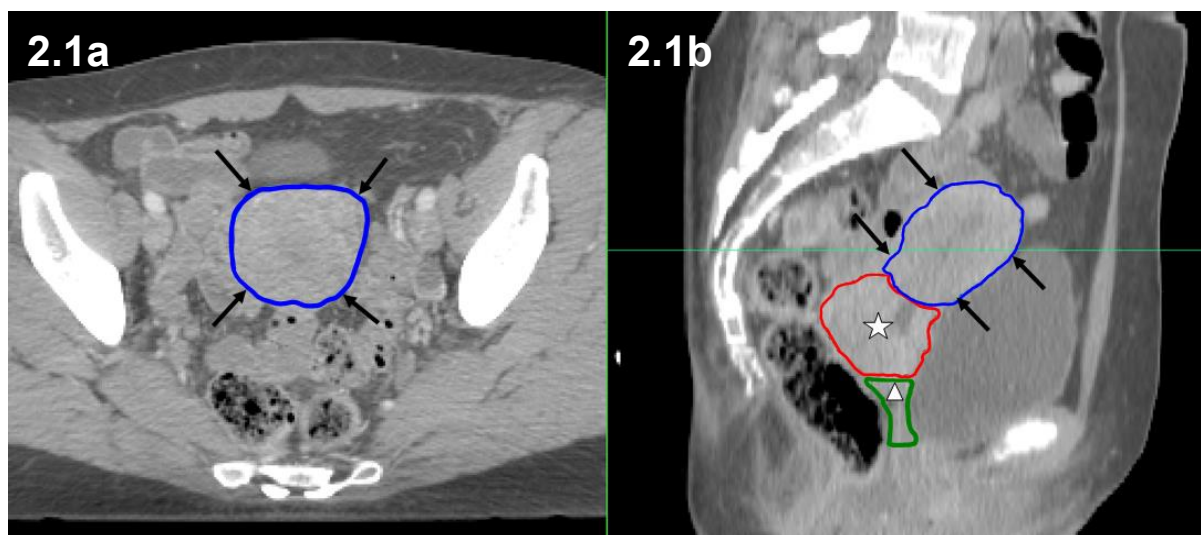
Transverse (a) and sagittal (b) CT with the uterine corpus outlined (arrowed). The uterine cervix (star) and vagina (triangle) can also be seen in b.
